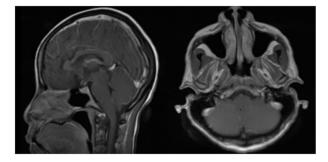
MRI of the brain with contrast in sagittal and axial view respectively. There is minimal mildly nodular leptomeningeal enhancement involving the bilateral cerebellar folia and enhancement along the optic chiasm, bilateral trigeminal nerves and Meckel's cave's as well as the bilateral internal auditory canals
